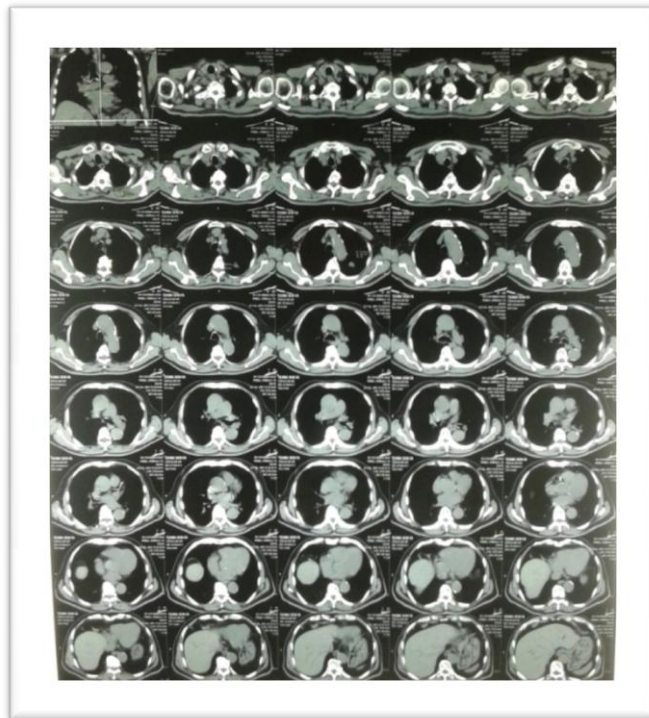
Computed tomography Thorax without kontras
